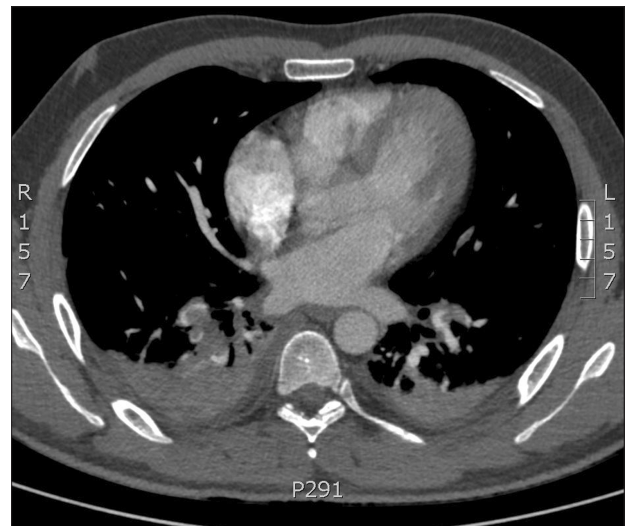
Thoracic computed tomography scan revealed pulmonary embolism in bilateral lower lobes.
